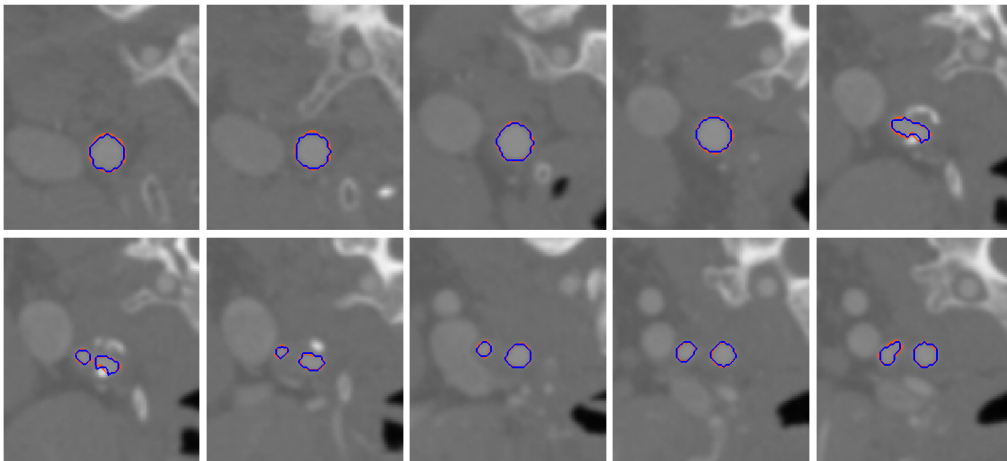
Comparison of geometry segmented from CT image dataset 4 using image slices taken along z-axis direction: blue - manual, orange - GPF deformable model.
